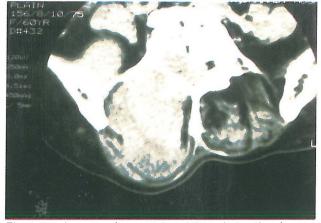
Axial computed tomogram at L5 level revealing destructive bone lesions, thecal sac compression and a paravertebral mass on the right side with sparse punctate calcification.
